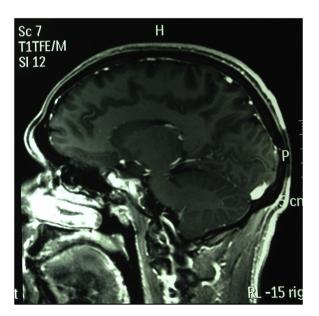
Latest magnetic resonance imaging (MRI) performed.
